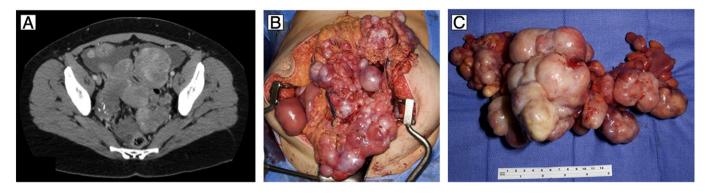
A) Preoperative CT image demonstrating multiple solid peritoneal masses. B) Intraoperative findings of multiple solid masses involving pelvic and abdominal viscera. C) Resected sigmoid colon with numerous nodules of inflammatory myofibroblastic tumor ranging from 1.0 cm to 13.5 cm in greatest dimension involving the serosa and mesentery.
